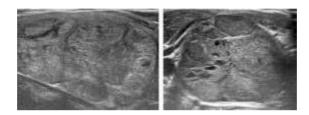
Thyroid Nodules Ultrasound Images
